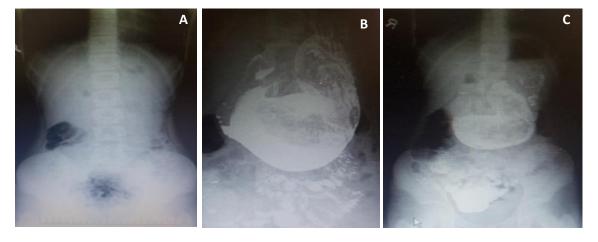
Abdominal X-ray: A - on an empty stomach; B - more than one hour after barium medium swallow; C - over 12-hour interval
